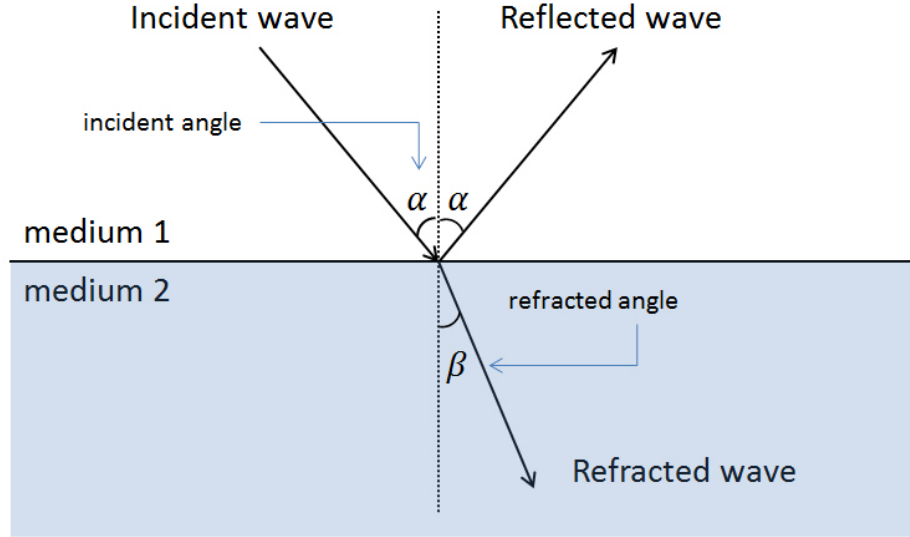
Ultrasound wave reflection and refraction on an interface of two mediums with different acoustic impedance.
